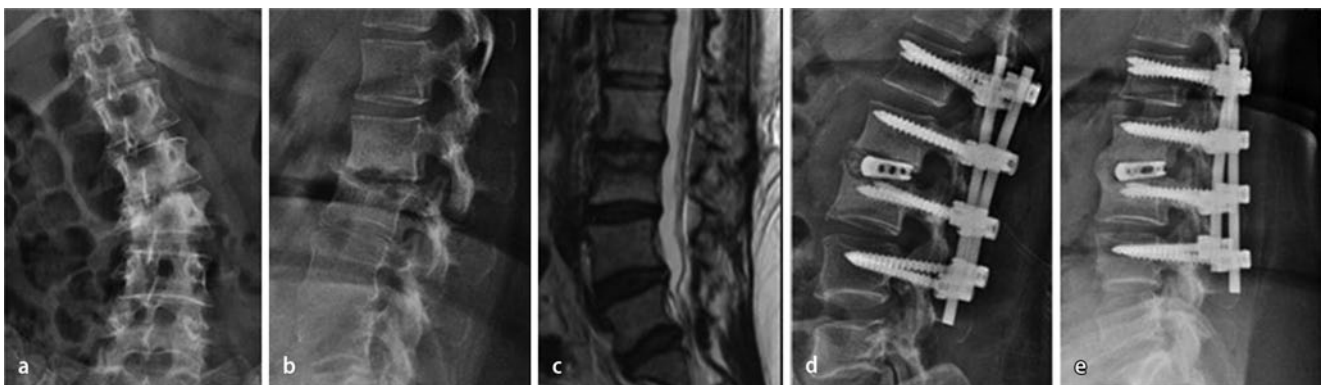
▲ a, b Anteroposterior and lateral radiographs show asymmetric collapse of L2–3 disc space and adjoining vertebrae. c Sagittal MRI shows the eroded disc space. d Posterior kyphosis correction with transforaminal reconstruction, which healed at 9 months (e)
